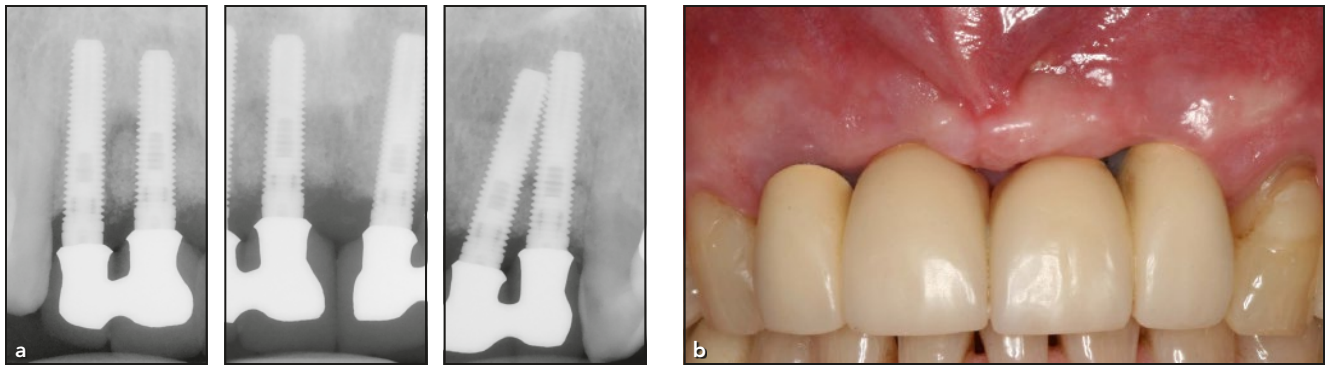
Radiographic (a) and clinical appearance (b) at 6 weeks postoperative.
